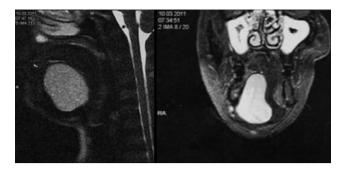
Magnetic resonance imaging (sagittal and coronal view) of the patient after presentation, showing the midface and head and neck region, highlighting the giant epidermoid cyst located in the right sublingual region.
